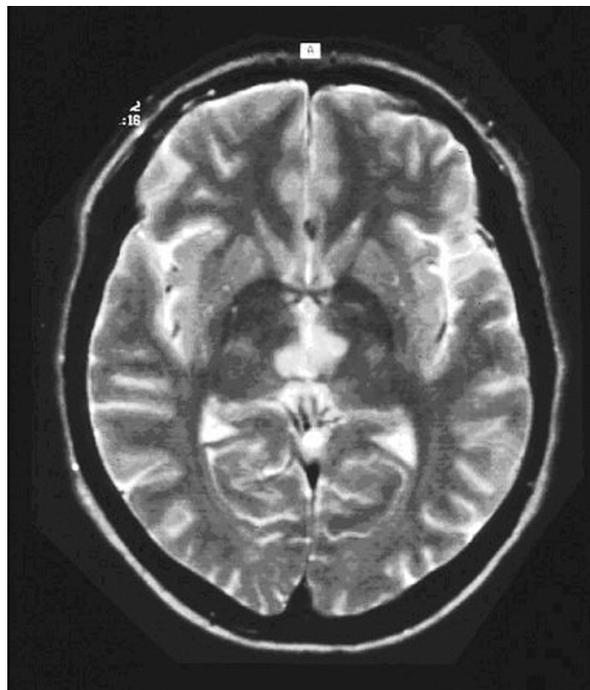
A bilateral paramedian thalamic infarction (MRI T2-weighted imaging).
